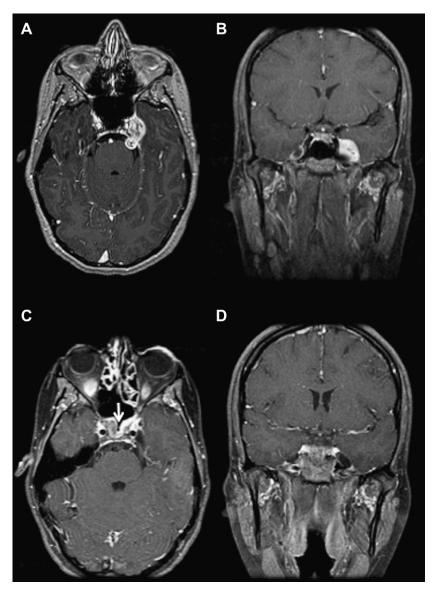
(A) Axial and (B) coronal preoperative magnetic resonance images showing a left Meckel's cave schwannoma in a 20-year-old female patient. This lesion, which presents a heterogeneously low to intermediate signal, occupies the inferior cavernous sinus compartment with PF projection. (C) Axial and (D) coronal postoperative magnetic resonance images after a Meckel's cave endoscopic endonasal approach through the lateral recess of the sphenoid sinus, demonstrating total removal of the lesion.
